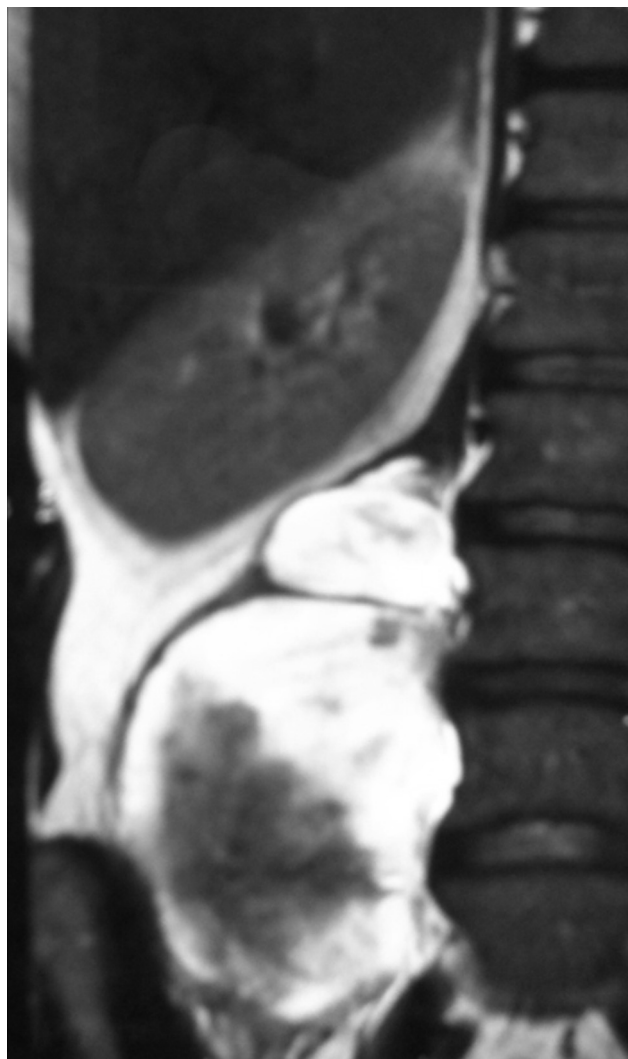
Frontal T2-weighted magnetic resonance imaging scans showing the paravertebral neoplasm in the contest of the right psoas muscle.
